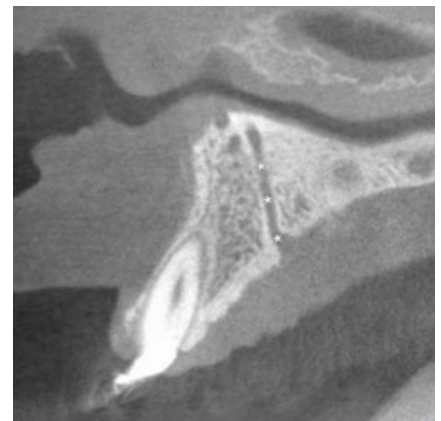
Sagittal CBCT image
